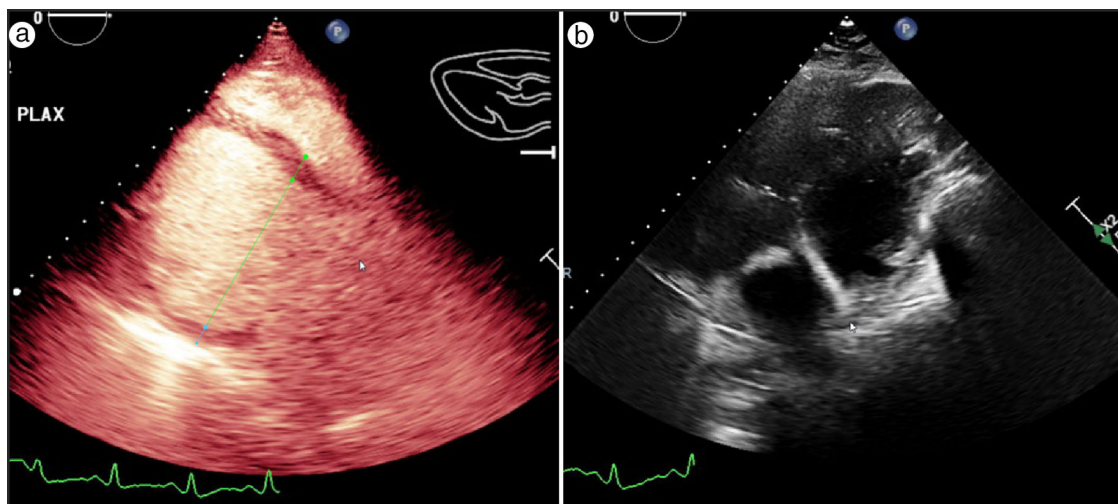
Transthoracic echocardiogram with contrast: (a) parasternal long axis view showing a dilated left ventricle; (b) substernal view showing LVAD canula in the left ventricular cavity.
